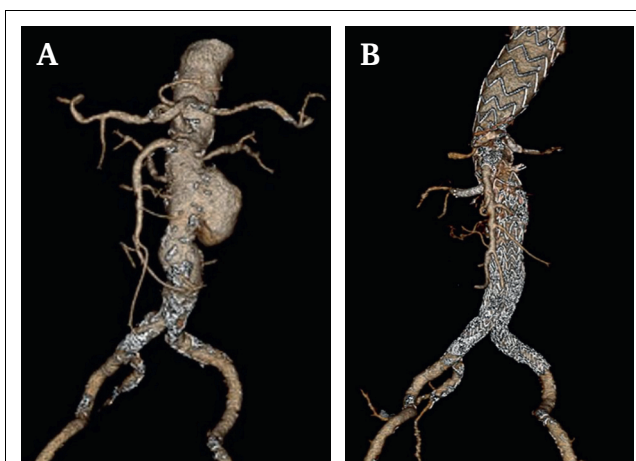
3D reconstruction of (A) the pre-operative computed tomography angiogram (CTA) of a large pararenal aortic aneurysm; and (B) the post-operative CTA after treatment with E-nside.
